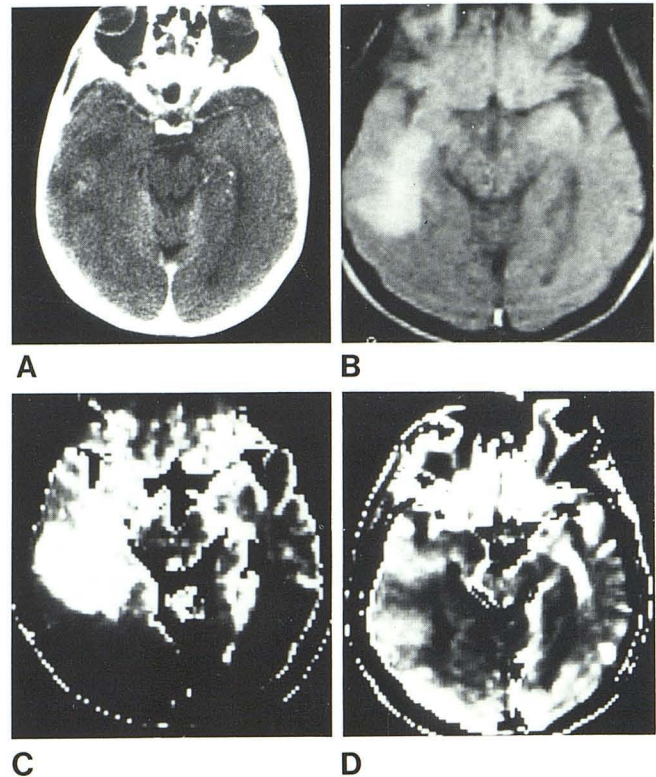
Subacute infarct. A, CT 4 days after right hemispheric infarction reveals inhomogeneous lesion with slight contrast enhancement in right temporal lobe. B, SE NMR image shows area of high intensity 17 days after insult. Calculated images indicated prolongation of T_2 relaxation (bright area, C) is responsible for this intensity; T_1 in lesion was similar to normal brain (D).
